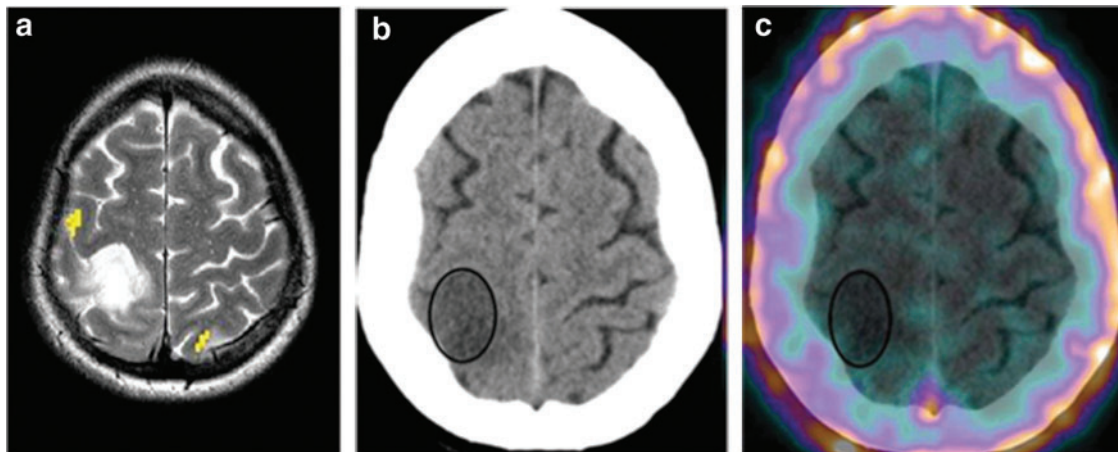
PET/CT brain images of a patient with GBM associated to metastatic primary lung tumor (patient 016), collected at 1 hour after injection of $^{64}\text{CuCl}_2$ and showing cerebral lesions.
